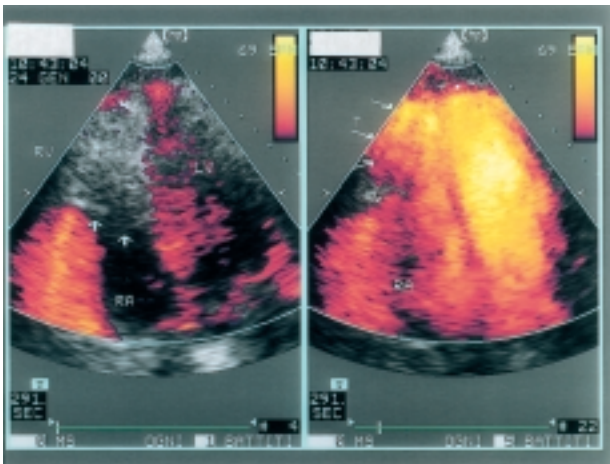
Two-dimensional intravenous echocontrast study, same view as figure 2. The left ventricular myocardial perfusion is detected in harmonic power Doppler mode. Left panel: before intravenous infusion of Levovist the echogenic mass (arrows) is visible in the apical portion of the RV. Right panel: during infusion of Levovist. The appearance of the contrast medium within the mass (arrows) at exactly the same time as in the LV, the interventricular septum and the apical/lateral walls of the LV suggests the presence of a common coronary arterial supply. T = tumor mass. Other abbreviations as in figure 2.
